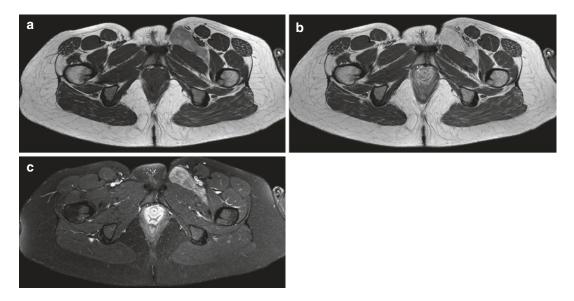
(a–c) Hibernoma of the left groin. (a) Axial unenhanced SE T1-weighted image. Mass between the femoral neurovascular bundle and the pectineus muscle, hyperintense to muscle, and hypointense to fat, resulting in an excellent tumor-to-fat contrast. (b) Axial Gd-enhanced SE T1-weighted image. The strong Gd
